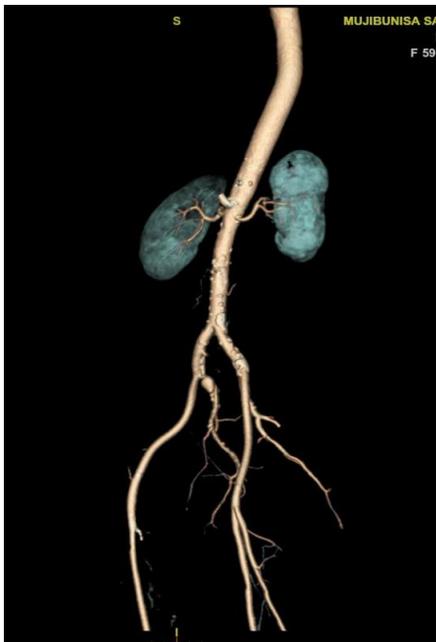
CTA-Right IIA Aneurysm
